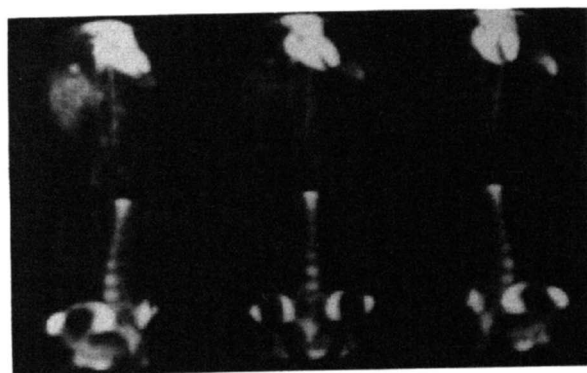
Volume rendering in “hot spot” imaging. (Top) hepatic blood-pool study demonstrating a small hemangioma at the dome of the liver. (Bottom) normal bone scintigraphy. Images were produced from several angles using depth-weighted maximum activity projection.
